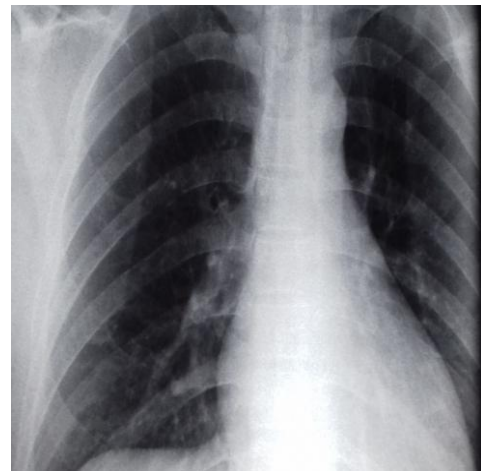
Chest radiograph prior to discharge (Case 1)
